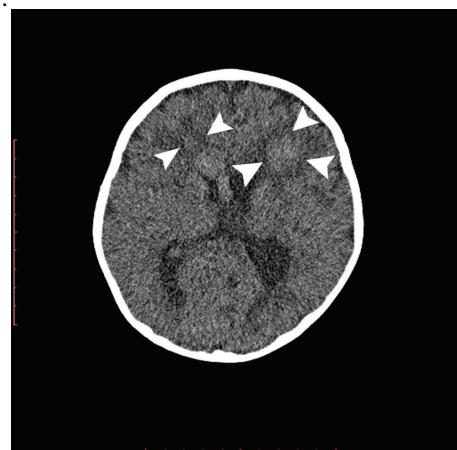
Brain CT showed peripherally hypodense lesions (arrowheads)
